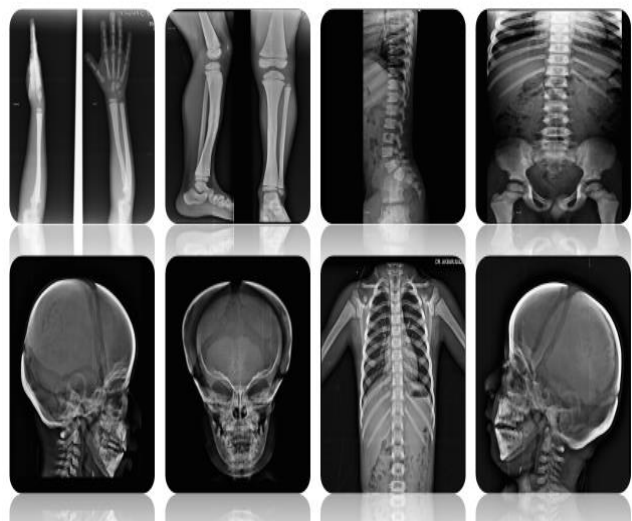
X-rays showing Pyknodysostosis
